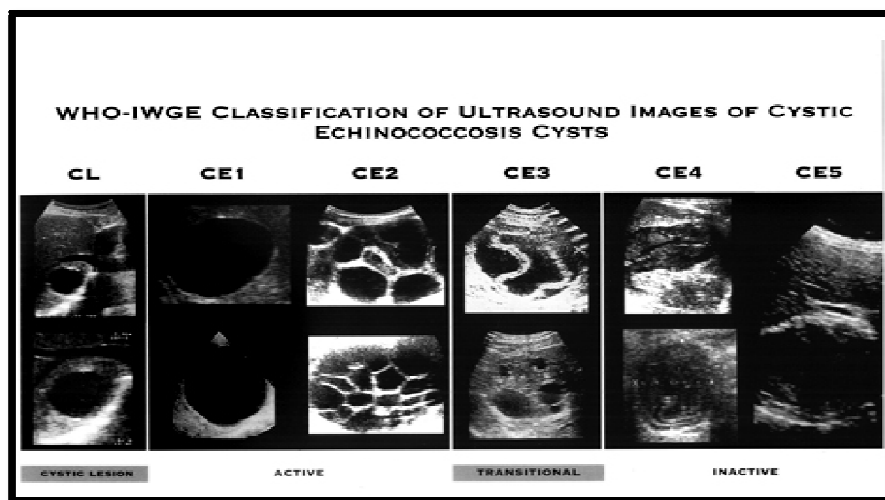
WHO classification of hadatid liver cysts according to images obtained by ultrasound
